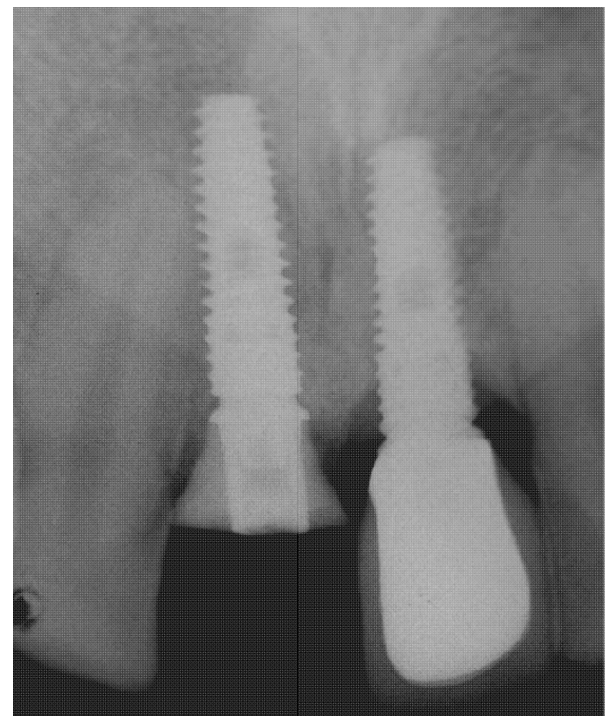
Postoperative periapical radiograph control showing implant position
